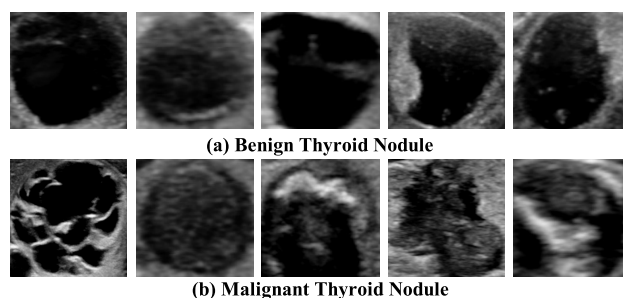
Some examples of benign and malignant thyroid nodules in ultrasound image. Images in first line are benign, and others are malignant.
